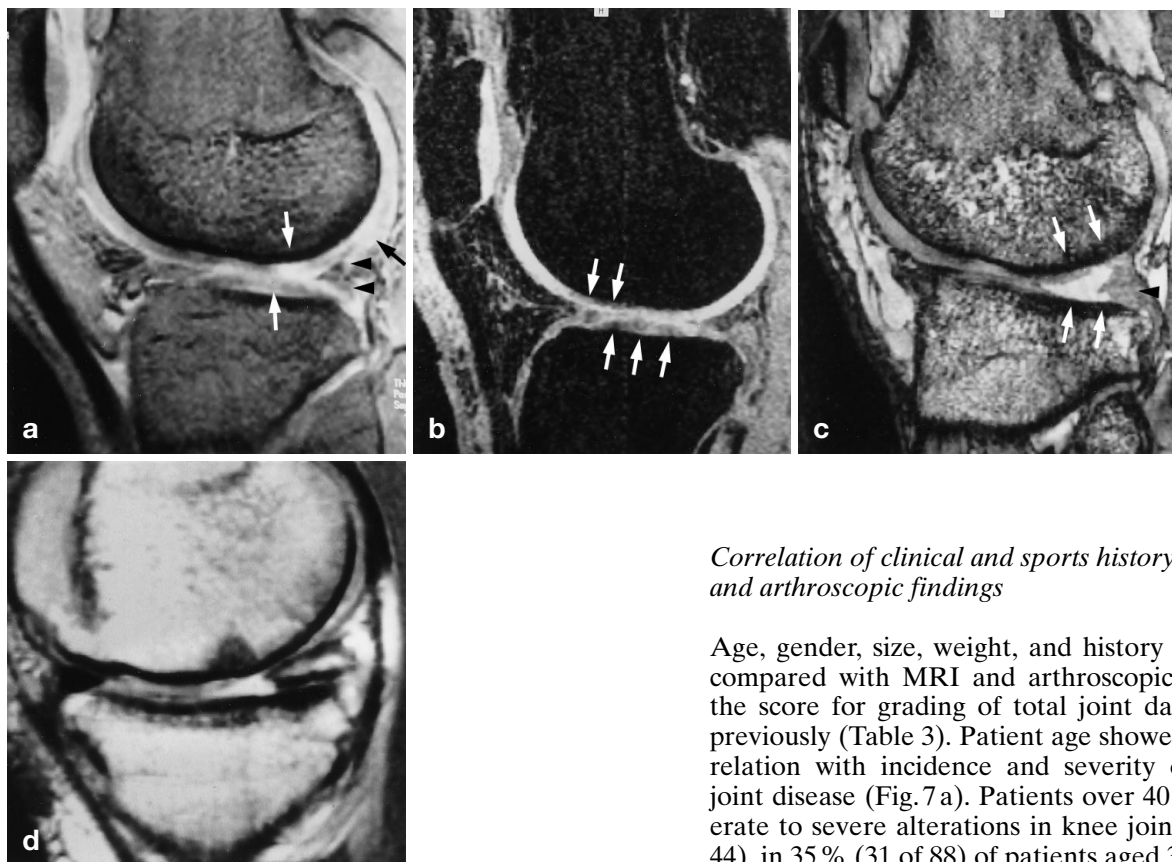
Demonstration of degenerative changes in cartilage and meniscus on MRI. a Signal increase in cartilage of lateral condyle and tibial plateau without thinning (arrows). A 24-year-old soccer player after subtotal resection of the lateral meniscus (arrowheads; 3D FISP) with grade-1 and grade-2 lesions at arthroscopy. b Superficial and signal changes in cartilage are at the limit of resolution with 3D FLASH sequence with fat suppression (arrows). Arthroscopy of this 27-year-old jogger showed grade-2 lesions on condyle and tibial plateau. c Advanced degeneration of cartilage (28-year-old soccer player). MRI with 3D FISP shows chondromatous defects on condyle and tibial plateau (arrows) adjacent to subtotal resected meniscus (arrowhead). Grade-3 and grade-4 lesions at arthroscopy. d Patient (34-year-old soccer player) with severe alterations in the knee joint. Nearly complete loss of cartilage and advanced degeneration of the posterior horn of the medial meniscus (SE sequence; TR/TE = 2000/20 ms)
